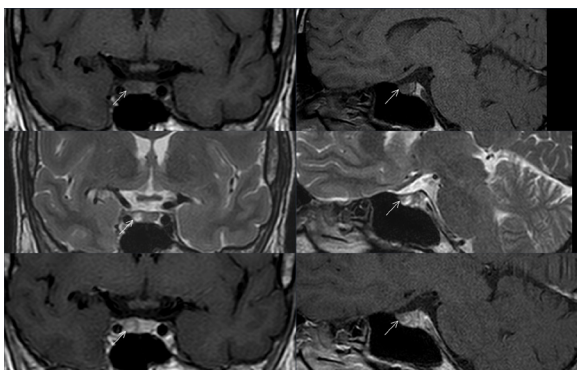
Images of pituitary magnetic resonance imaging at diagnosis revealing a microadenoma (indicated by the arrows).
